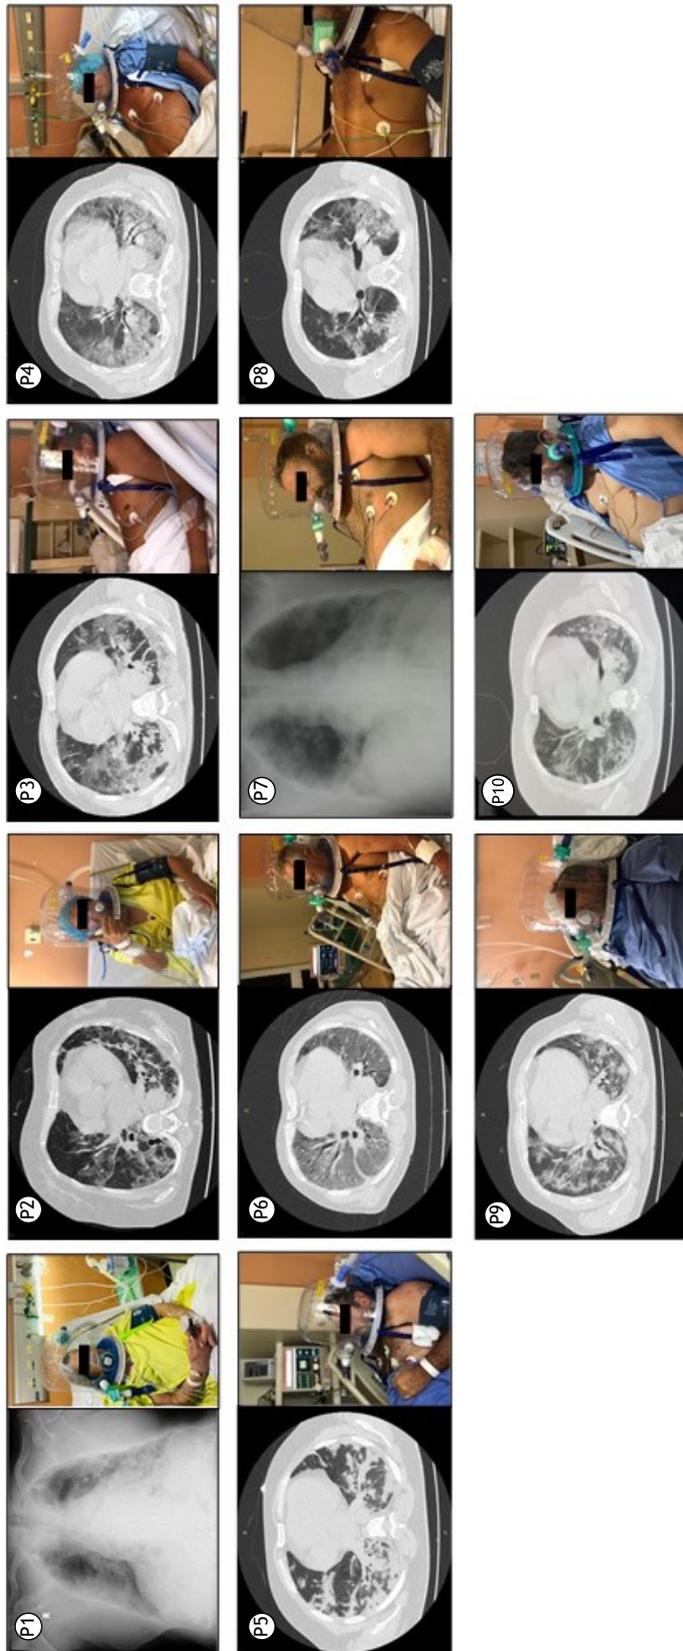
CT or X-ray images of the patients (P1-P10) taken within 24 h before the first ELMOcpap session and photographs of the patients during a session.
